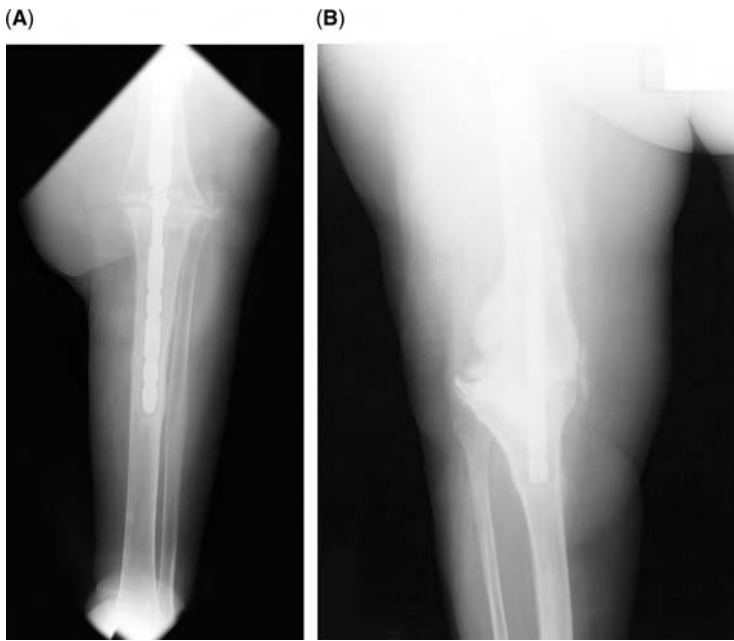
(A and B) Radiographs demonstrating two failed knee arthrodeses with two different types of short intramedullary devices.
